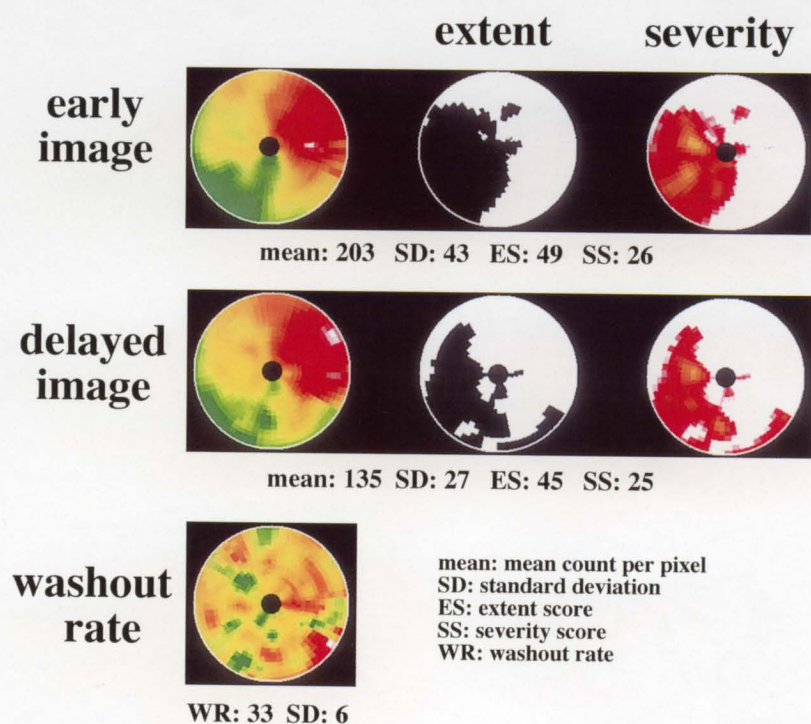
Bull's eye, extent and severity maps. Quantitative findings of ^{201}Tl SPECT in a patient with DCM were calculated using a computer system.
